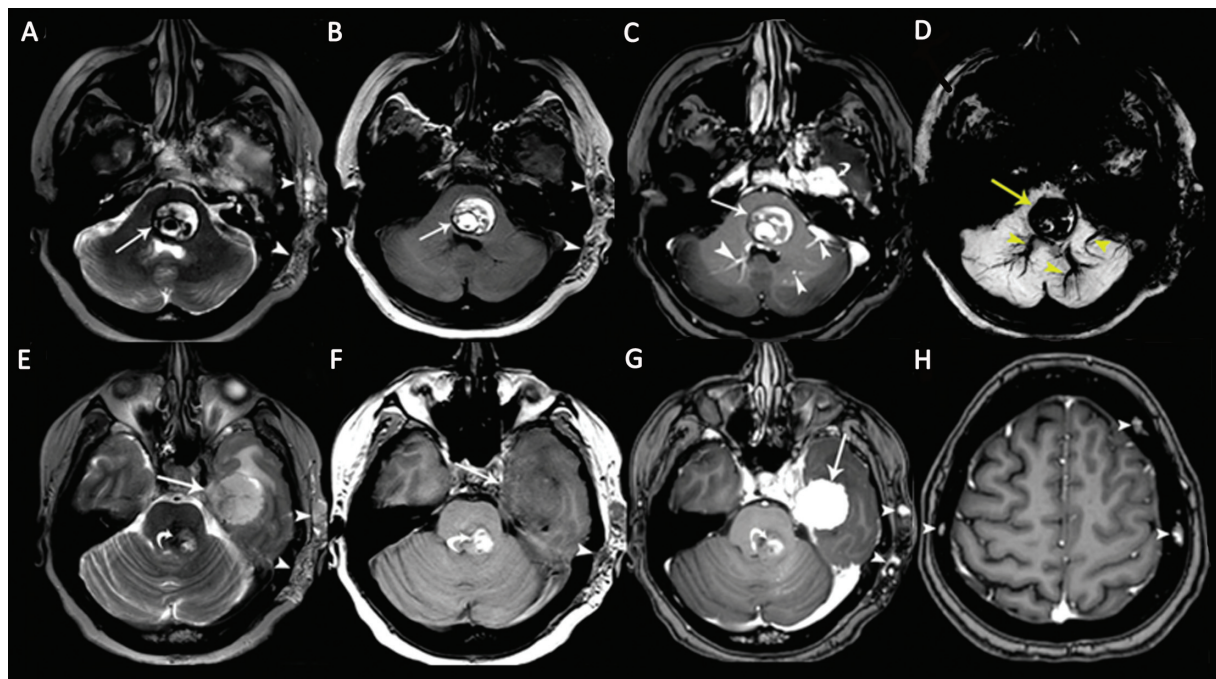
A 48-year-old woman patient with multiple cavernous malformations (CMs) associated with a cavernous sinus hemangioma. Axial (A) T2-weighted image (T2WI) and (B) T1-weighted image (T1WI) show a pontine CM with heterogeneous signals and peripheral hemosiderin deposits (arrows) associated with soft-tissue hemangioma in the left temporal subcutaneous area (arrowheads). (C) Contrast-enhanced axial T1WI shows nonenhancing CM (arrow), enhancing developmental venous anomalies (DVAs; arrowheads) in the brainstem, and an enhancing dural cavernous hemangioma in the left middle cranial fossa (curved arrow). (D) Pontine CM and DVAs show “blooming artifacts” on susceptibility-weighted imaging (SWI). (E) Axial T2WI shows a large dural cavernous hemangioma in the left middle cranial fossa with heterogeneous hyperintense signals (arrow). There is also a brainstem CM (curved arrow) and a soft-tissue hemangioma in the left temporal subcutaneous area (arrowheads). (F) The dural cavernous hemangioma in the left middle cranial fossa is hypointense on the axial T1WI. The soft-tissue hemangioma in the left temporal subcutaneous tissue is hypointense on the image (arrowhead). (G) The dural cavernous hemangioma in the left middle cranial fossa shows intense homogeneous enhancement on contrast-enhanced T1WI (arrow). The brainstem CM shows no enhancement (curved arrow). Soft-tissue hemangioma in the left temporal subcutaneous tissue shows a few dotlike enhancing areas, representing dilated veins. (H) Axial contrast-enhanced T1WI shows multiple calvarial CMs (arrowheads).
